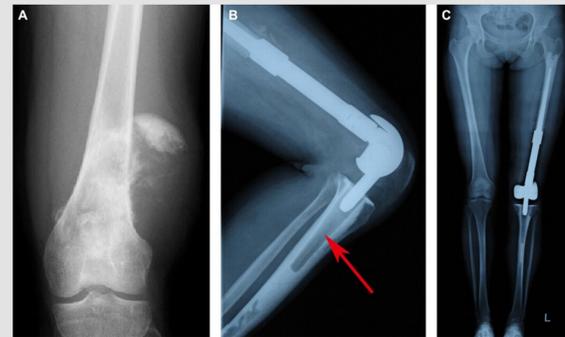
X-ray images of an osteosarcoma patient whose left distal femur tumor was treated with an all-polyethylene tibial endoprosthesis replacement. Image A: preoperative AP view of knee; Image B: postoperative lateral view of knee in flexion; Image C: postoperative lower extremity view. A tumor endoprosthesis replaces the missing body part inside of the patient's body.
